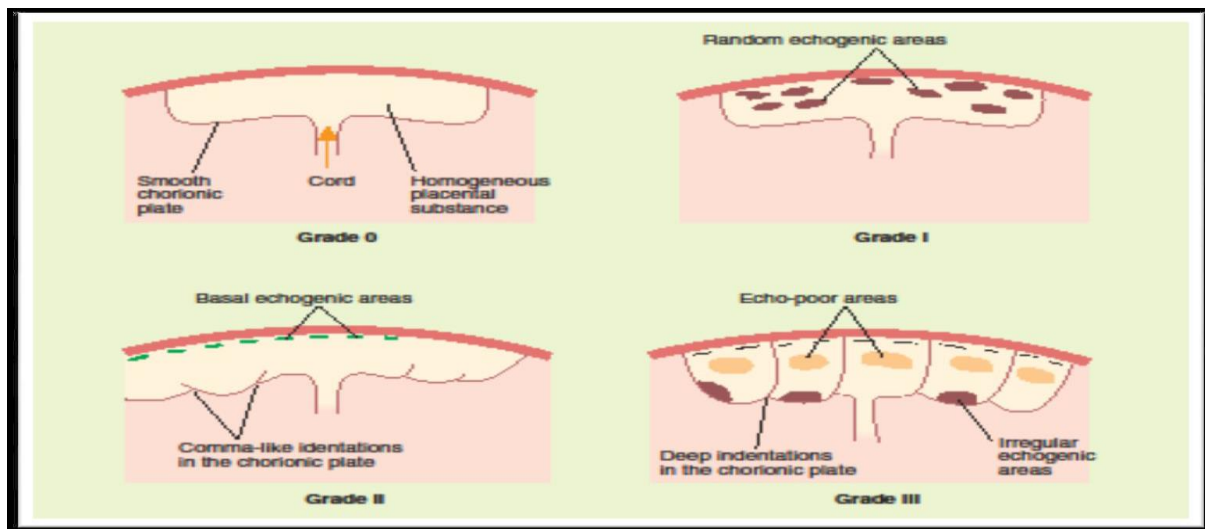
show the ultrasound appearance of placental grading(Chudleigh & Thilaganathan., 2004)
